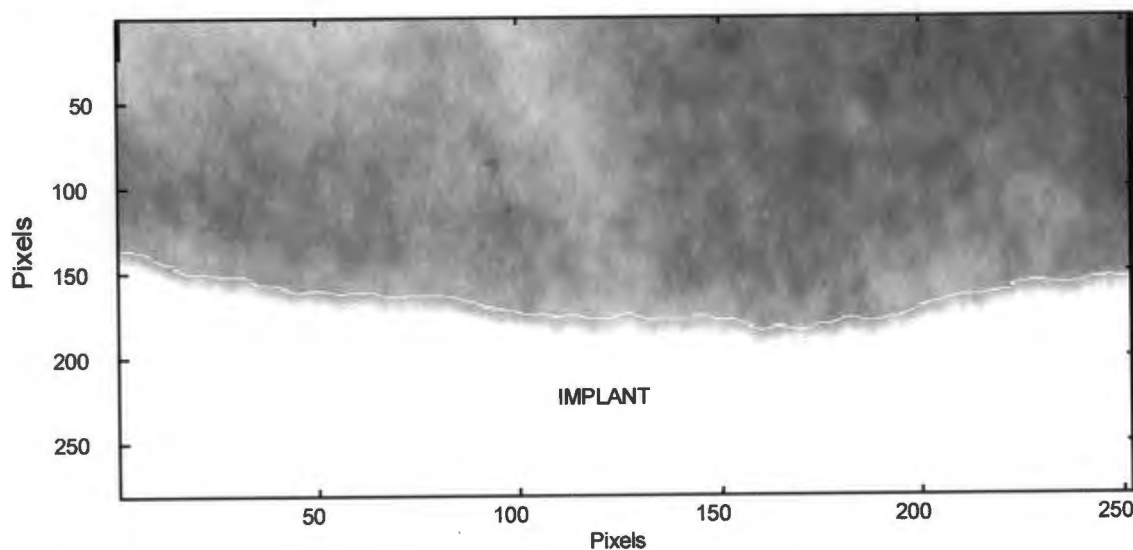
Section of X-ray image showing shape of detected implant edge (white line).
